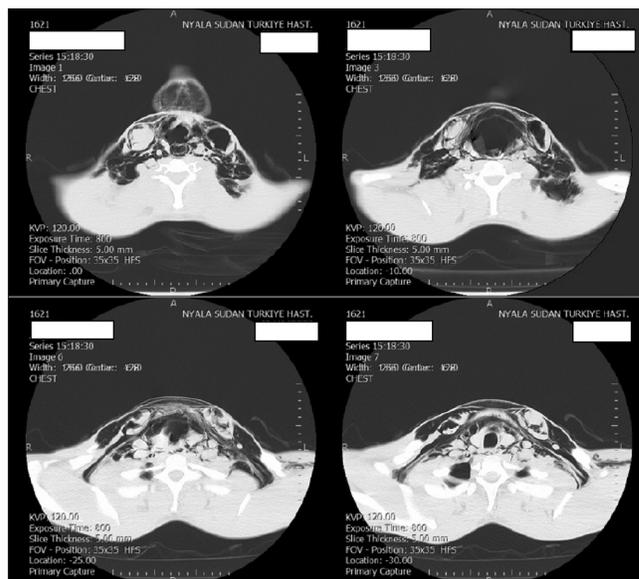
Thorax computed tomographic scans
